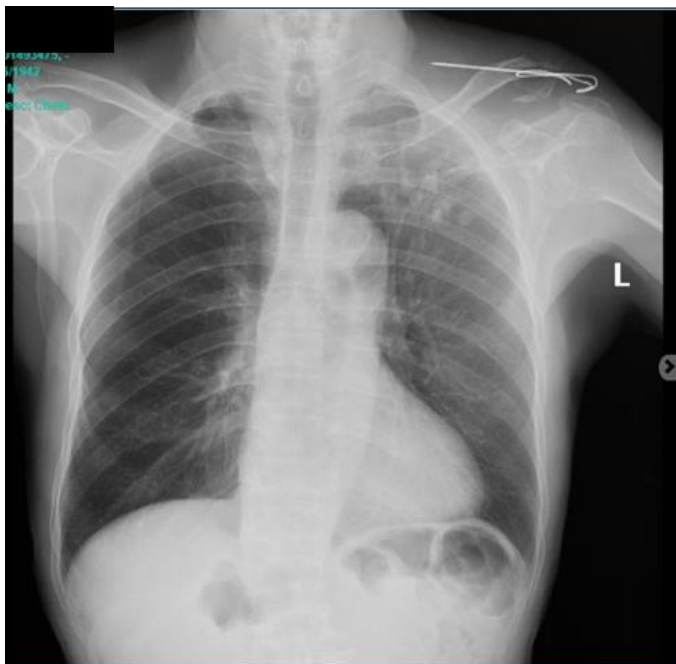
Chest x-ray showing active pulmonary tuberculosis with the extensive lesion, aortosclerosis, and internal fixation attached to the lateral 1/3 of the left clavicle.
